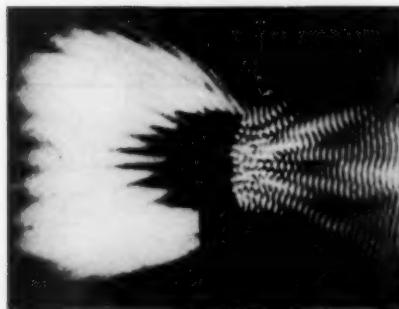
Pattern of standing waves and increase of intensity between flanges of a Smith-Peterson nail. Ultrasound beam incident from the right.
